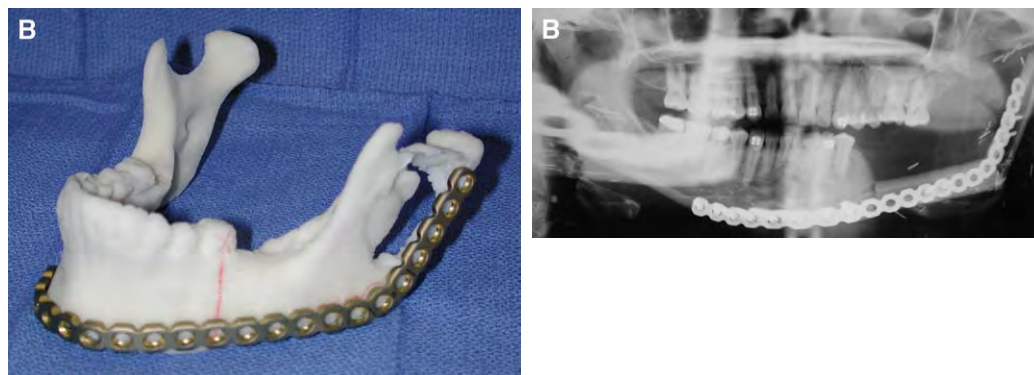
(A) The use of a CAD-CAM model to adapt the reconstruction bar in a case of a hemimandibulectomy, including the articulation of the mandible. (B) A panoramic radiograph shows the early postoperative appearance of the flap.
